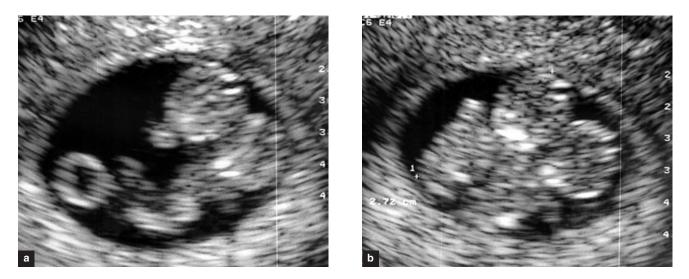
(a) Transvaginal sonogram of a pair of monoamniotic (MA) twins with one yolk sac. (b) Transvaginal sonogram of a pair of MA twins with close proximity
